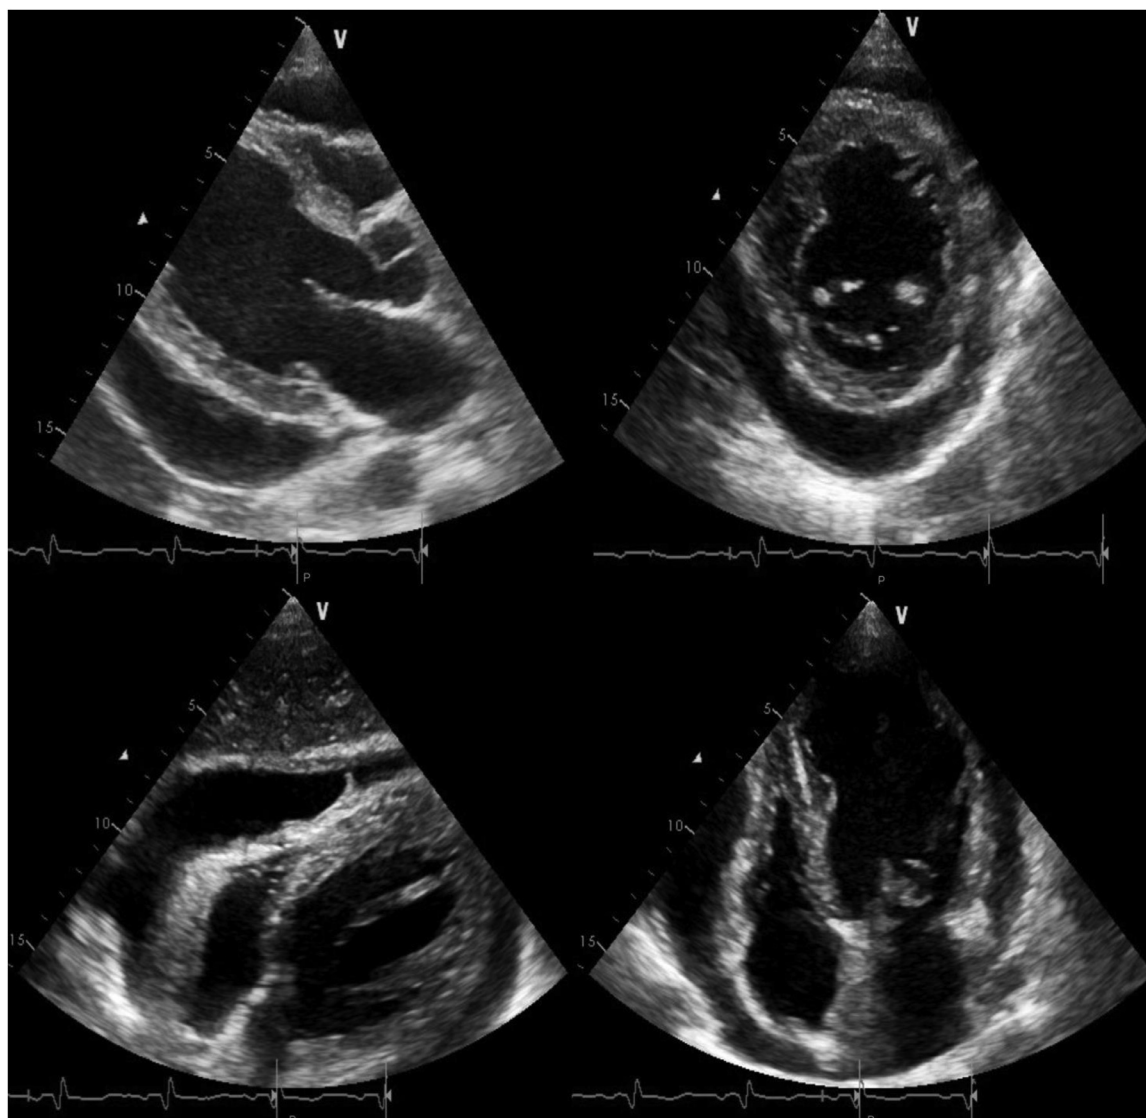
Transthoracic echocardiography revealing a large pericardial effusion.
